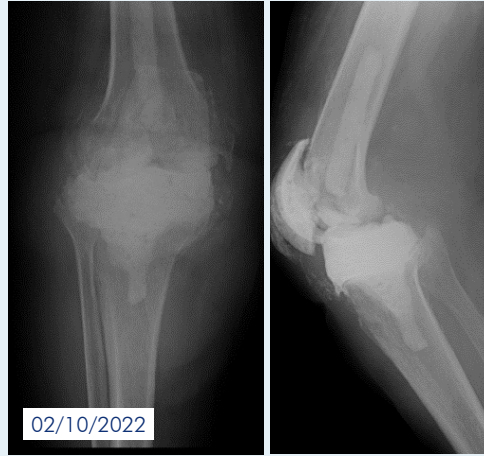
Radiographs at first clinic visit.
